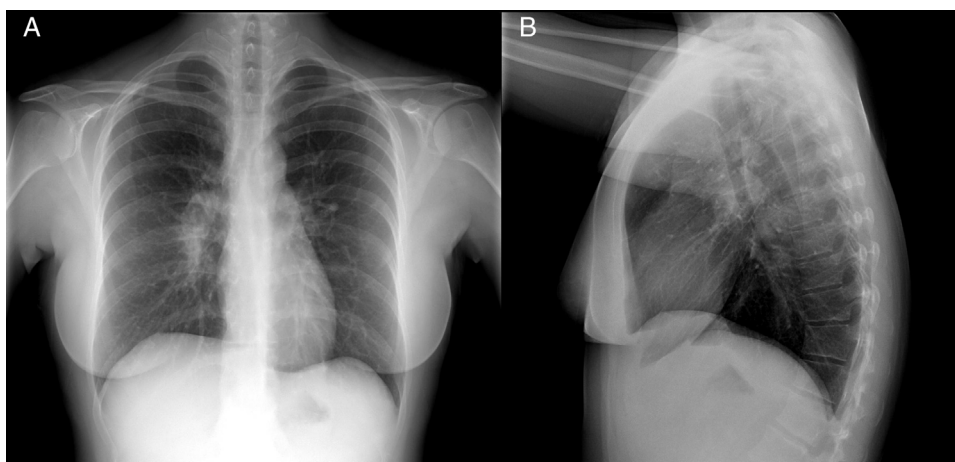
(A) Posteroanterior chest X-ray. (B) Lateral chest X-ray. Right hilar enlargement related to lymphadenopathy.
